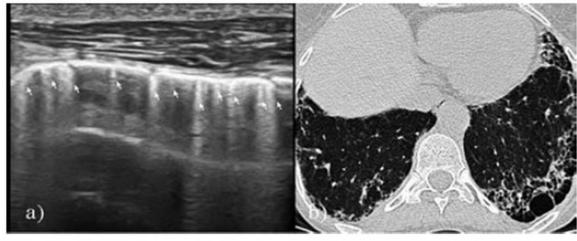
a) The comet tail sign (several B-lines) in the severe form of alveolo-interstitial involvement in systemic sclerosis. b) HRCT showed severe form of alveolo-interstitial involvement in systemic sclerosis (Warrick score = 30).
